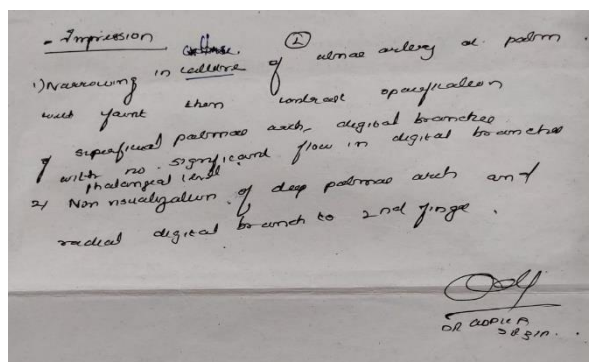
Report CT angiogram of left upper limb (14.09.21)
